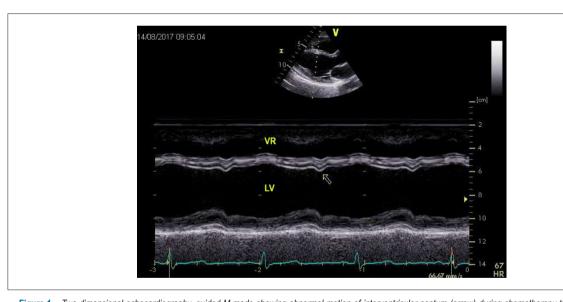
Two-dimensional echocardiography–guided M-mode showing abnormal motion of interventricular septum (arrow) during chemotherapy treatment. LV: left ventricle; RV: right ventricle.
